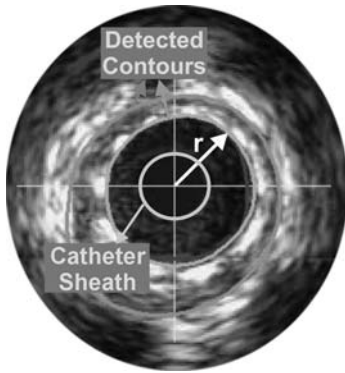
The increased propagation speed of the ultrasound signal crossing the catheter sheath was neglected in the BSC 30 MHz Ultracross[®] software in the Clearview[®] instrument. This must be taken into account for accurate radial, and thus also area measurements. Applying Equation 1 can retrospectively do this.
